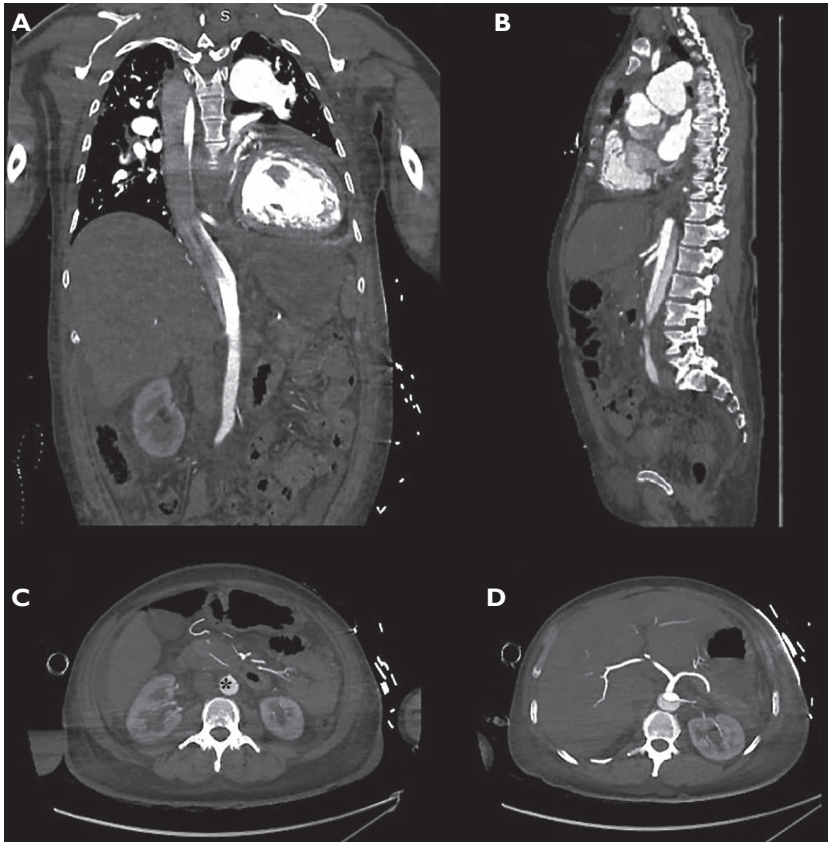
Computed tomography angiography scan images, showing in coronal (A) and sagittal (B) the extension of the dissection flap extended to the upper limits of the iliac bifurcation (shown in axial section, the lower limit of abdominal aortic dissection – C). The coronal section of the artery (B) is not entirely viewable given the scoliotic course of the abdominal aorta. With increased maximum intensity projection, the integrity of the celiac trunk is shown (D).
